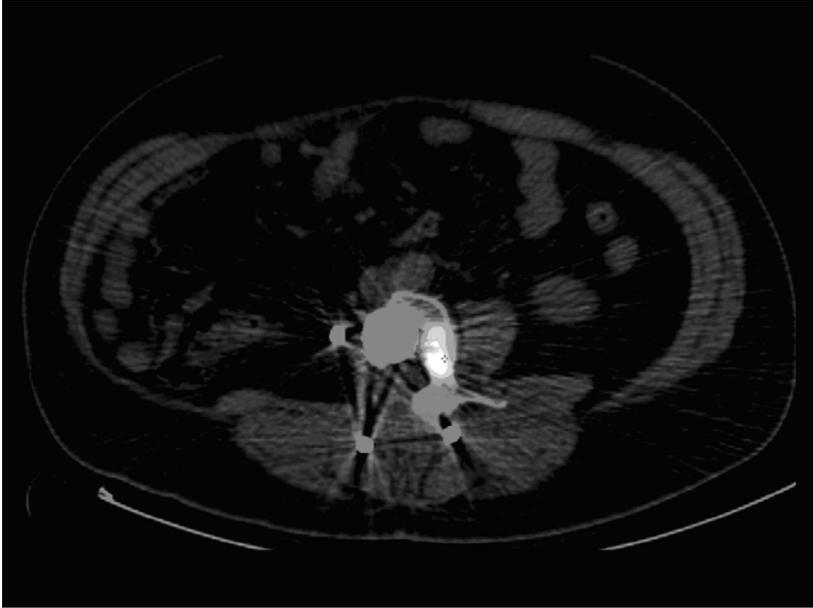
Patient with metastasized thyroid cancer. After extensive vertebral surgery and several treatments with ^{131}I , it remained unclear whether vital tumor tissue was still present. ^{124}I -PET-CT clearly shows iodine uptake (i.e. vital tumor) at the left side of the vertebra. Therefore, adjuvant high dose ^{131}I therapy is recommended for this patient.
